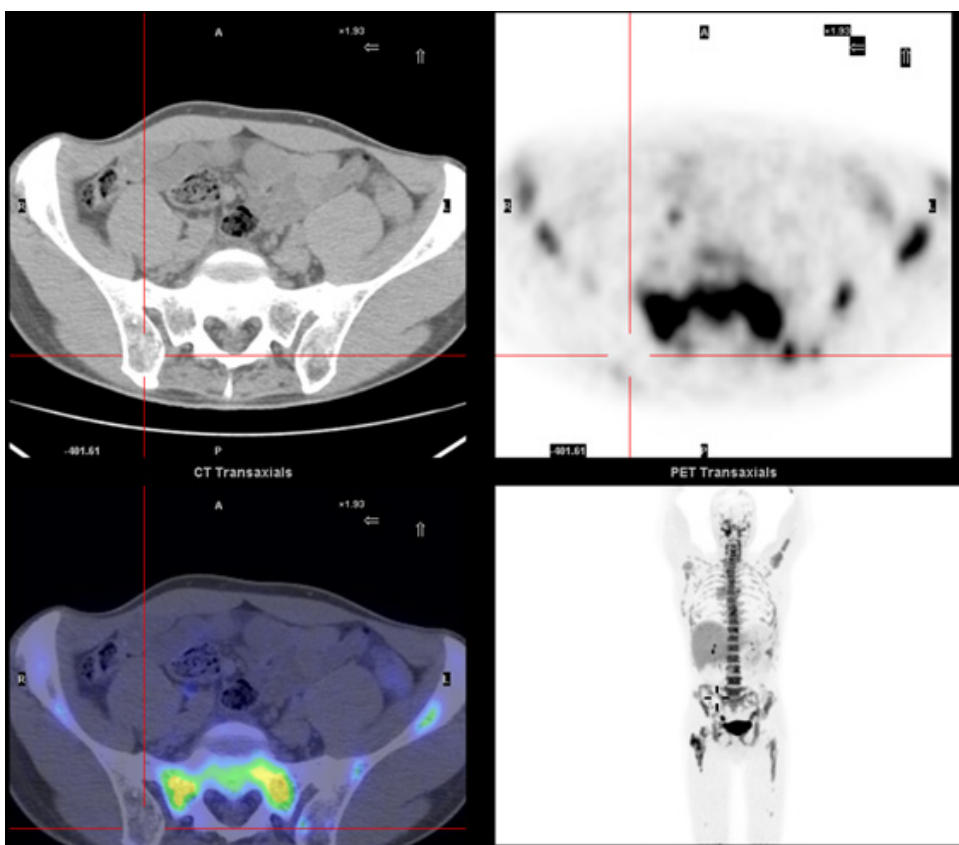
A 55-year-old man with stage IV diffuse large B cell lymphoma with nodal and multifocal bony disease and the pre-treatment bone marrow biopsy from the right posterior ilium showing hypocellular marrow and aplasia, in the presence of normal peripheral blood counts. ^{18}F -FLT PET/CT was performed, which demonstrated absence of proliferative tissue in the right posterior ilium but fairly normal distribution of hyperproliferative bone marrow elsewhere with no evidence of extramedullary haemopoiesis in the spleen or elsewhere. The ^{18}F -FLT PET/CT findings suggested that the initial bone marrow biopsy result was non-representative of his true bone marrow status and the patient went on to undergo systemic chemotherapy treatment without any myelotoxicity problem (Image courtesy of The Peter Mac Callum Centre).
